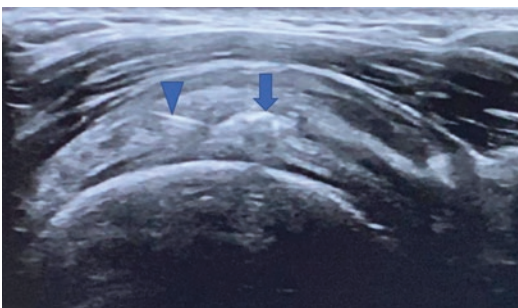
Sagittal image of an ultrasound exam: note the needle as a linear image (arrowhead) and a heterotopic calcification (arrow)
